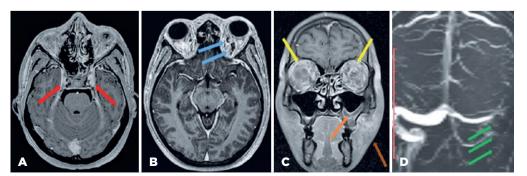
(A) Magnetic resonance imaging (MRI) showed features suggestive of bilateral cavernous sinus thrombosis (red arrow), (B) distended superior ophthalmic vein (blue arrow), (C) bilateral orbital cellulitis (yellow arrow), left maxillary sinusitis (orange arrow), and left cheek soft tissue swelling (brown arrow), (D) left sigmoid dural sinus thrombosis (green arrow).
